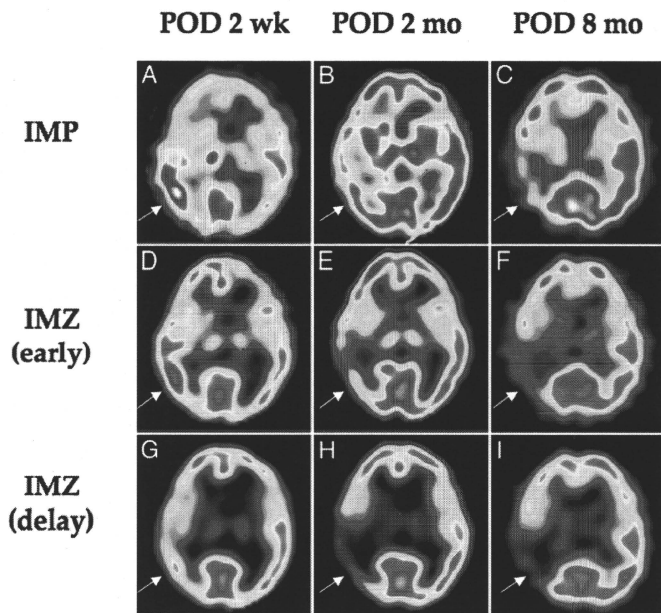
Chronological changes in  $^{123}\text{I}$ -IMP and early and delayed  $^{123}\text{I}$ -IMZ SPECT images. Iodine-123-labeled iodoamphetamine (A–C) and early  $^{123}\text{I}$ -IMZ (D–F) images similarly showing a transient increase in the subacute stage (POD 2 weeks [POD 2 wk; A and D]), followed by progressive decrease in the early and late chronic stages (POD 2 months [POD 2 mo; B and E] and 8 months [POD 8 mo; C and F]) of uptake in the affected regions. Delayed images of  $^{123}\text{I}$ -IMZ (G–I) demonstrating delayed decrease of binding of the affected regions between subacute (G) and early chronic (H) stages, which levels off in the late chronic stage (I). Arrows indicate the affected region in the temporal lobe.
